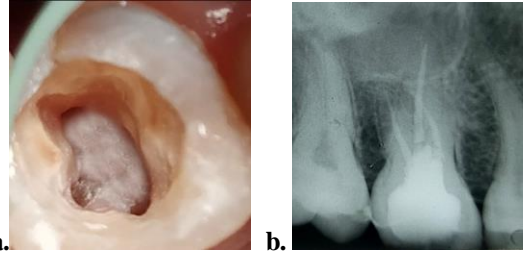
Representing type, I canal configuration in the mesiobuccal root. a. Photograph of access cavity, b. Post-obturation x-ray
